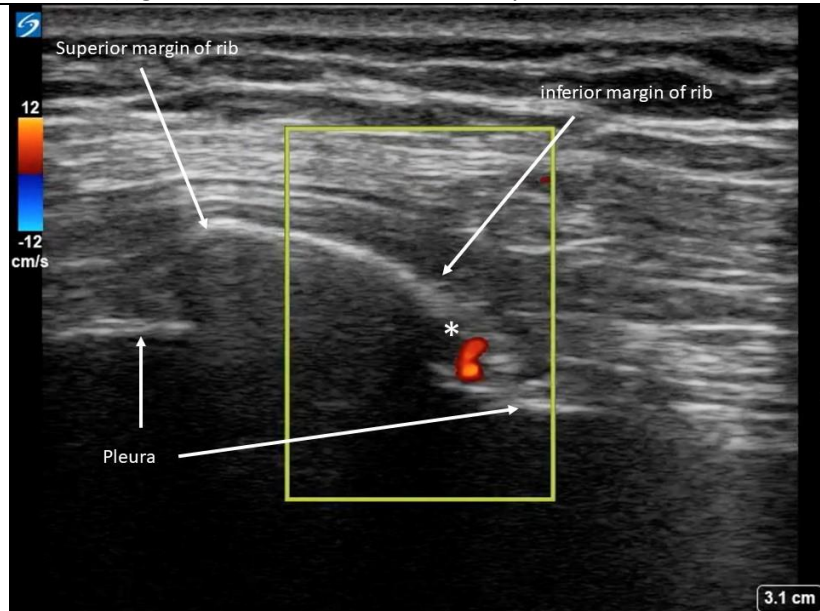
Evaluating for the presence of intercostal vessels with colour Doppler.
